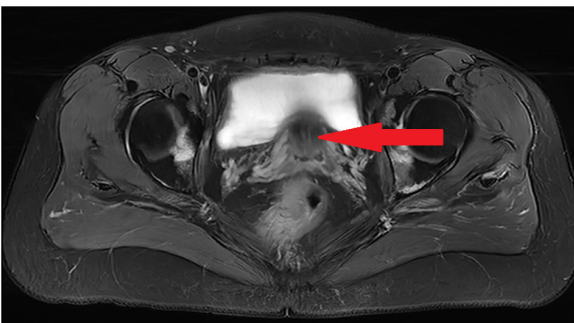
Follow-up pelvic MRI. The arrow indicates the location of the cervical metastatic lesion after treatment, which shows a marked reduction in size.
